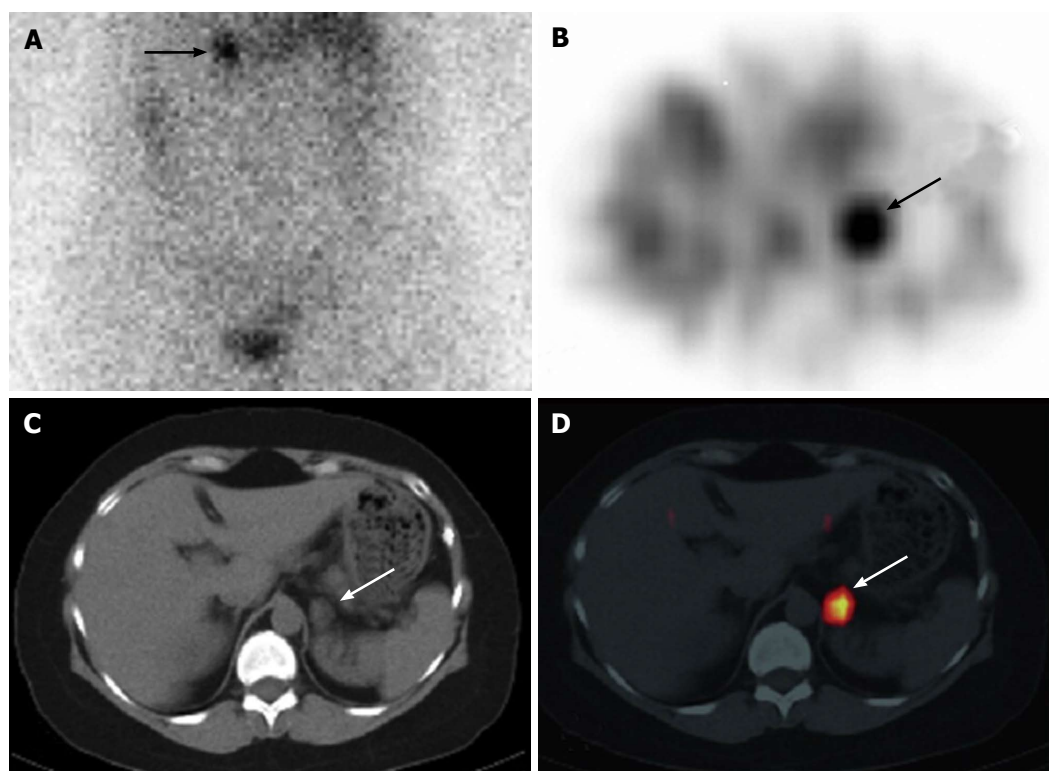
A 55-year-old woman with Cushing syndrome underwent ^{131}I -NP-59 single photon emission computed tomography/computed tomography scan for localization of Cushing's adenoma. Planar posterior (A) abdominal image on day 5 post injection of ^{131}I -NP-59 SPECT/CT demonstrates focal uptake in the left adrenal region (arrow). Transverse SPECT (B), CT images (C) and fused SPECT/CT (D) localize activity to a 1.5 cm \times 1.8 cm nodule arising from the left adrenal gland (arrows). Findings are compatible with a hyperfunctional left adrenal adenoma. Imaging courtesy of "Adrenal Cortical Imaging with I-131 NP-59 SPECT-CT". (By Wong *et al.*^[161], with permission). SPECT: Single photon emission computed tomography; CT: Computed tomography.
